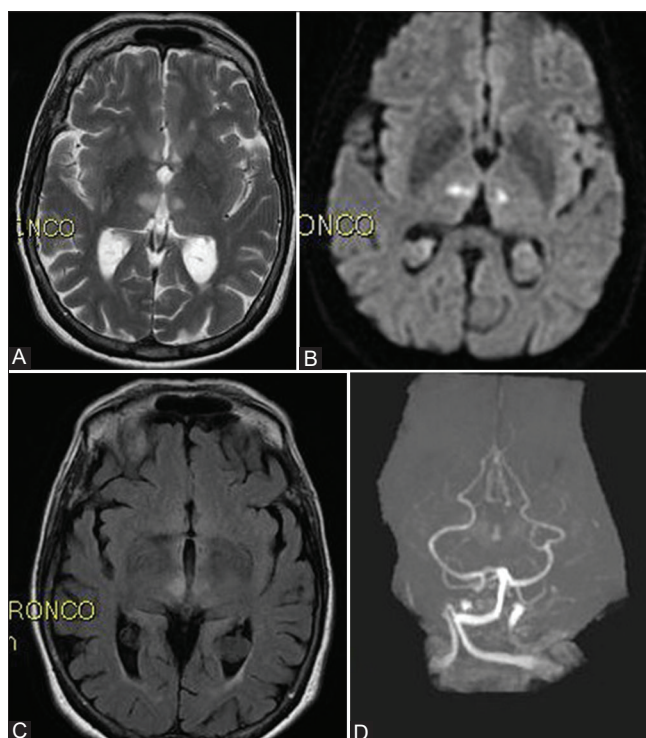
(A) T2 FRFSE sequence: Bilateral thalamic infarction. (B) Diffusion-weighted imaging sequence: Bilateral thalamic infarction. (C) T2 flair: Bilateral thalamic infarction. (D) Angio-magnetic resonance imaging: Normal basilar apex.
